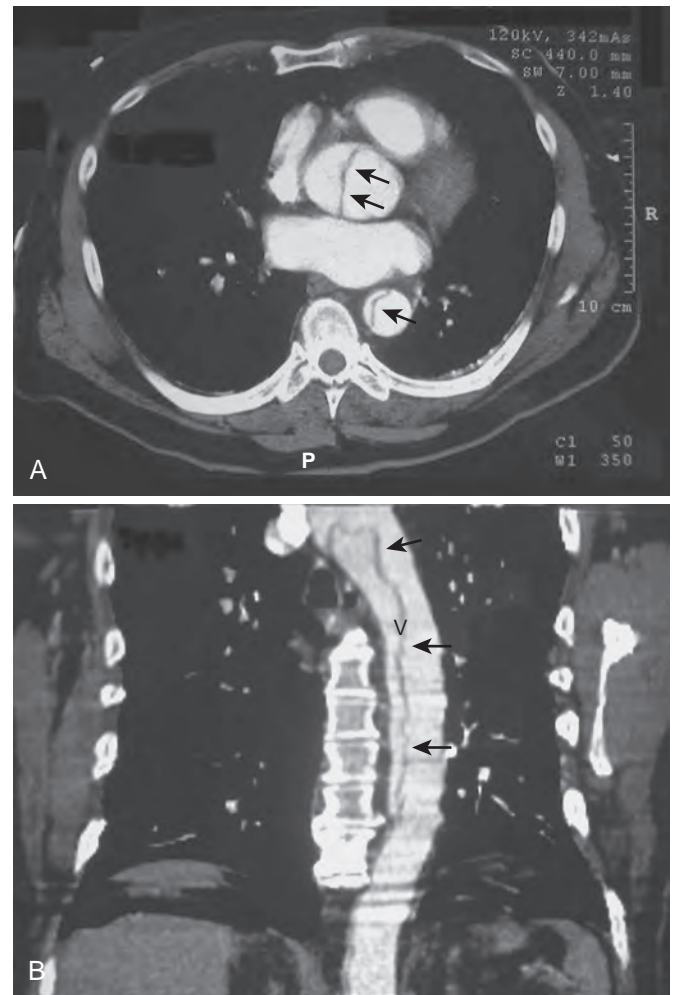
Computed tomographic angiogram in a patient with a type A aortic dissection. Axial images of the chest (A) demonstrated an intimal flap that extended from the ascending aorta (double arrows) into the descending thoracic aorta (single arrow). Sagittal reconstruction (B) demonstrated the presence of an intimal flap in the descending thoracic aorta (single arrows).
